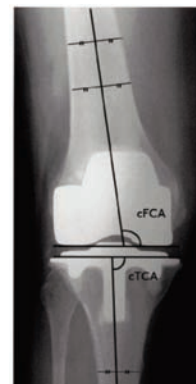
Radiographic assessment of the femoral and tibial components as proposed by the Knee Society.
